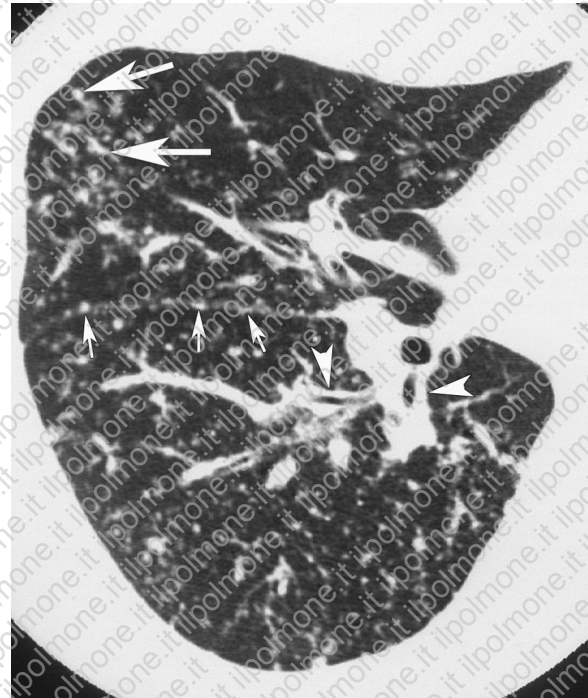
Pulmonary sarcoidosis in a 24-year-old man. High-resolution chest CT scan demonstrates multiple miliary nodules and diffuse thickening of the bronchial wall (arrowheads). Note the simultaneous presence of small nodules with a perivascular distribution (large arrows) and along the interlobular pleura (small arrows).
